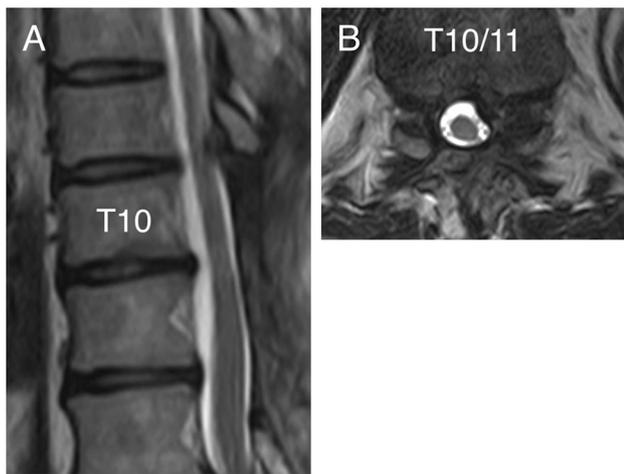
Case 2. MR images obtained after the first operation. Sagittal (a) and axial (b) T2-weighted images show the presence of cerebrospinal fluid around the spinal cord at the T10–11 level, and the spinal cord was sufficiently decompressed
